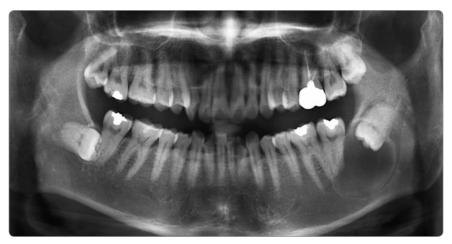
Pre-op radiography
